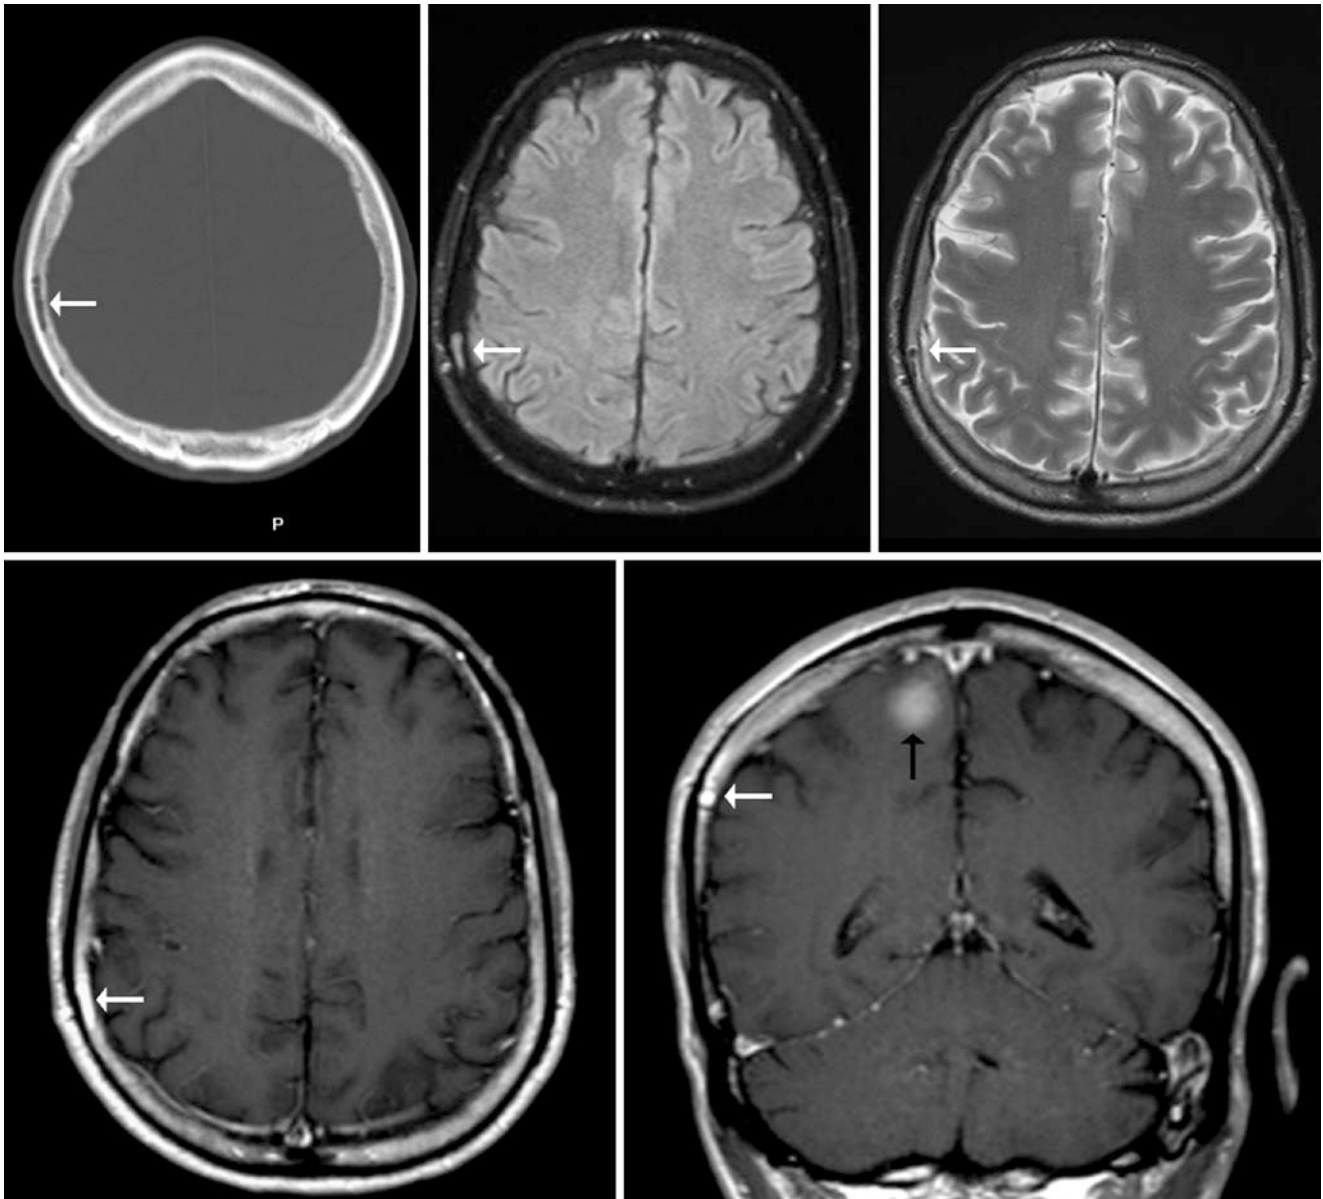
A 75 year old with melanoma; NECT and MRI were performed to rule out metastases. *Top row*: a lytic-appearing focus within the right parietal bone on NECT (*left*) is bright on FLAIR (*middle*) but
